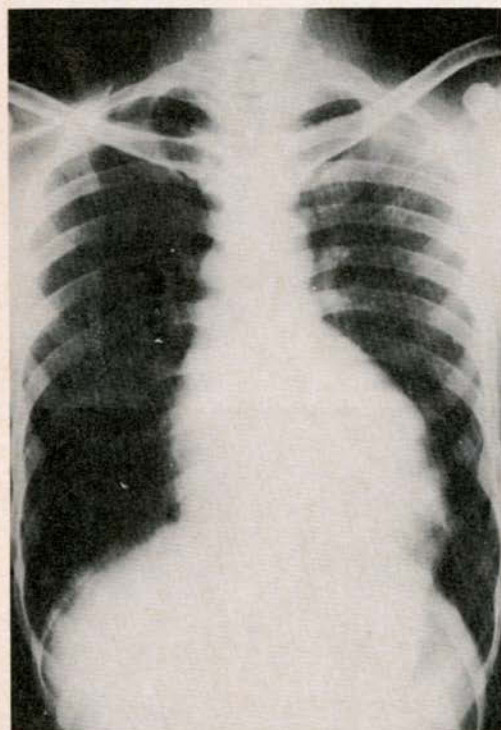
X-ray picture of the chest showing enlarged cardiac silhouette with prominent aorta.
